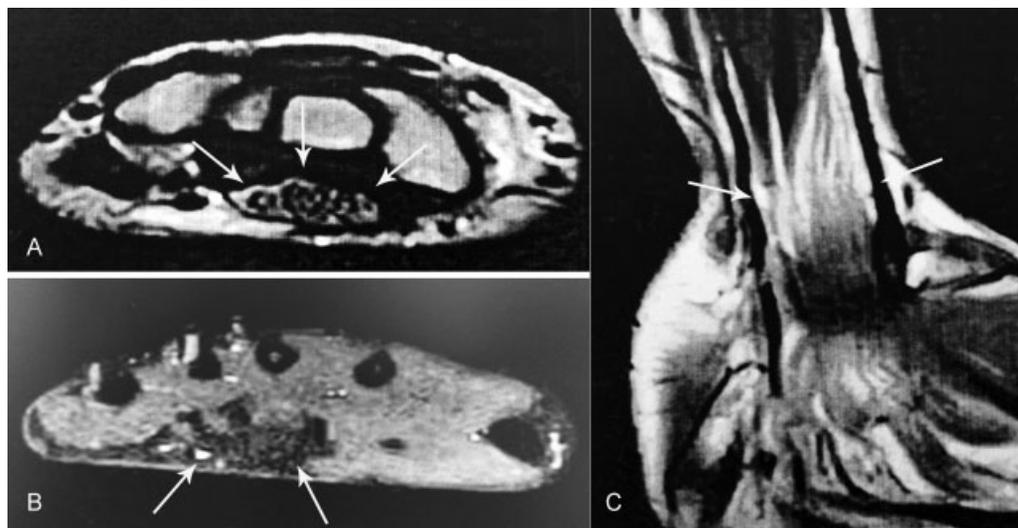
Fibrolipomatous hamartoma of the median nerve. (A) Axial T1-weighted, (B) axial fat-suppressed T2-weighted, and (C) coronal T1-weighted images show marked thickening of the median nerve with adipose tissue surrounding the nerve fascicles (arrows).
